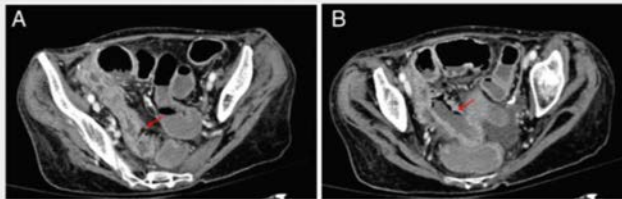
CT axial image during venous phase. Figure A shows a marked wall thickness (arrow) at the level of pre terminal ileum. Figure B shows a thicker wall of the ileum, with the presence of air (arrow), which is a typical sign of *pneumatosis intestinalis*, the lumen is enlarged. These finding suggest the presence of necrosis of the ileum wall.
